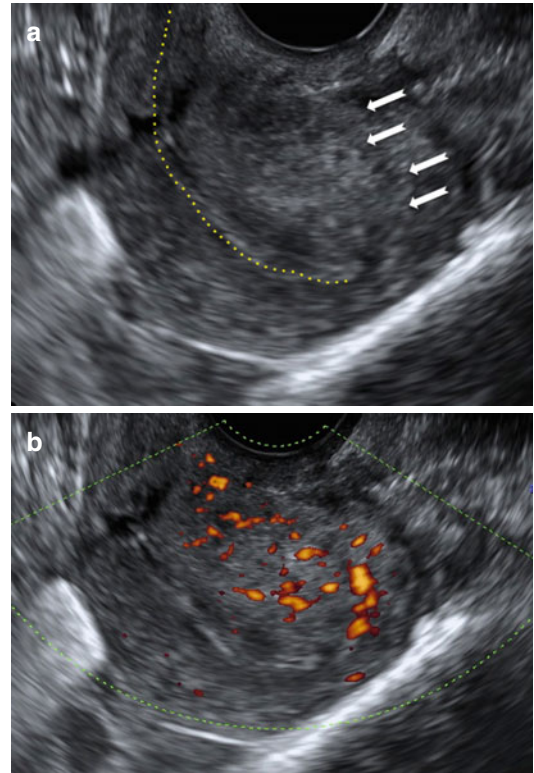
Ultrasound images of a retroverted uterus with adenomyosis with the typical 'question sign'. (a) Gray scale image showing asymmetrically thickened posterior uterine wall with abnormal echogenicity (white arrows). (b) Power Doppler image showing diffusely spread small vessels
